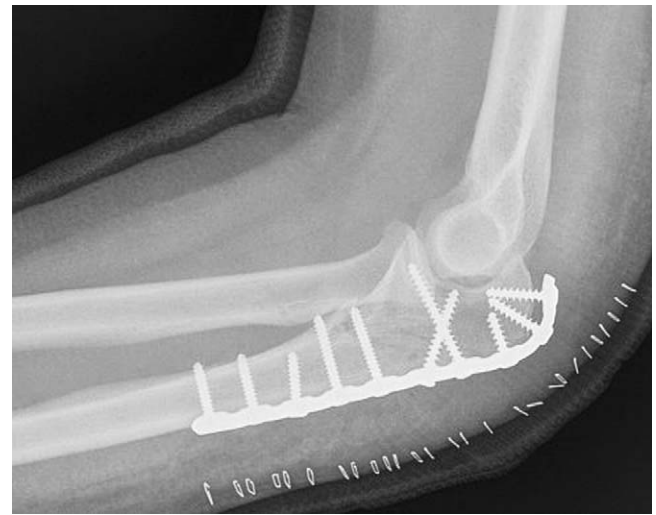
Lateral radiograph of plating and screws for olecranon fracture.
